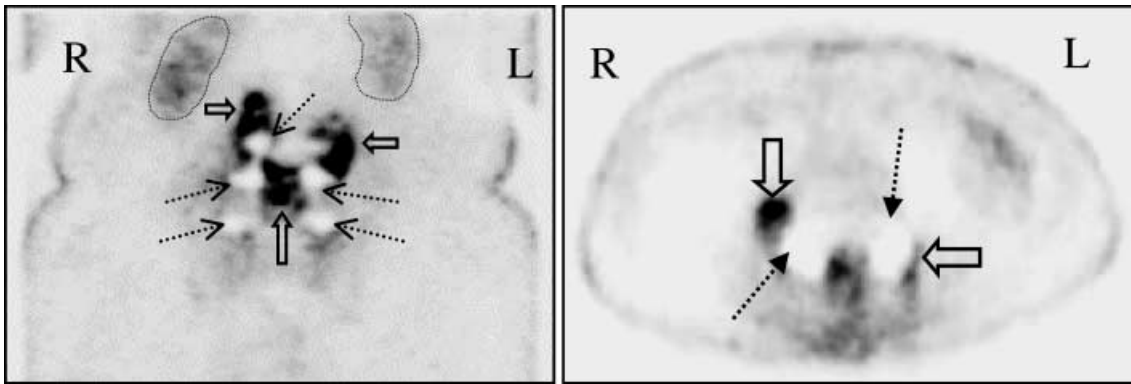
A patient with lumbar osteosynthesis material and low back pain. In these circumstances, bone scan, leucocyte scan and MRI are not contributory. Coronal (left) and transaxial (right) FDG PET showed intense glucose metabolism (thick arrows) adjacent to the osteosynthesis material (dotted-line arrows). At surgery, a pus collection was found adjacent to the osteosynthetic implants
